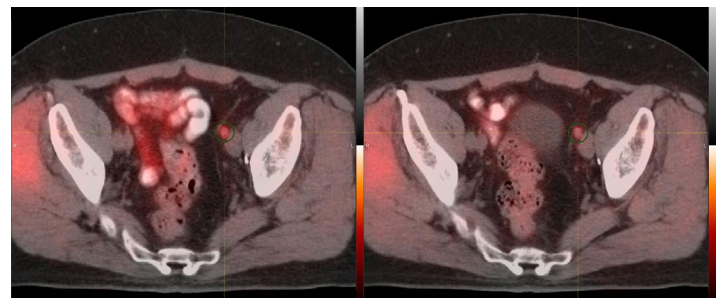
71 y/o, Gleason 7, treated with prostatectomy 15 years previously. Rising PSA at the time of AC PET/CT imaging was 0.87 ng/mL. Multiple nodal and bony lesions were positive in this patient. Only 1 example node is shown. The left image shows a sub-centimeter focally metabolic lymph node in the left proximal common iliac region on early imaging (SUVmax 2.43, L/B 1.94). The right image shows the same finding in the lymph node on the later imaging but with this appearing less conspicuous (SUVmax 1.77, L/B 1.7).
